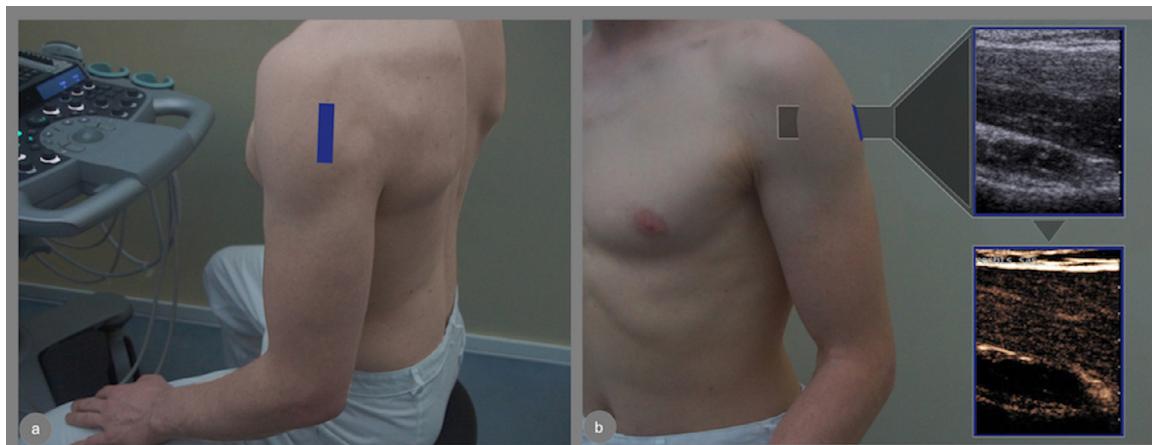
Primary scan plane for contrast-enhanced ultrasound examination of the deltoid muscle tissue. (a) Longitudinal transducer orientation at the transition between the acromial and spinal portion of the muscle. (b) Corresponding B-mode and contrast mode ultrasound images; focus and depth settings optimally adapted. Informed patient consent for publication available.
